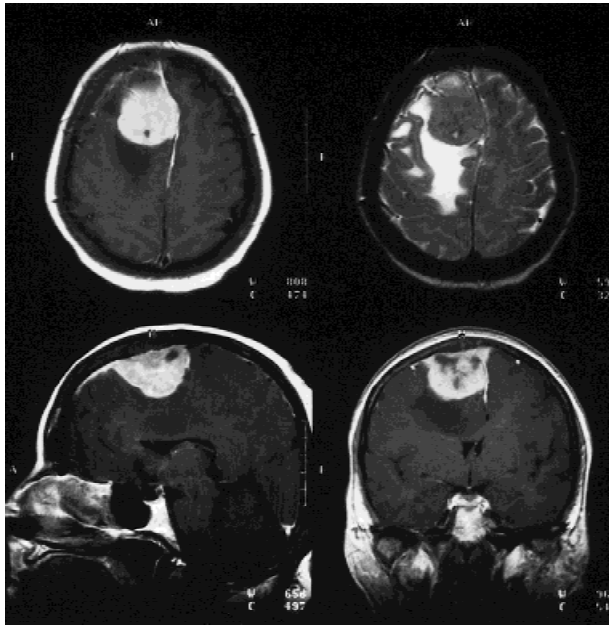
T1-weighted MRI scan showing a right-sided frontoparietal meningioma with areas of low density corresponding to focal calcification. The tumor is surrounded by a large perifocal edema resulting in considerable midline shift and compression of lateral ventricles.
